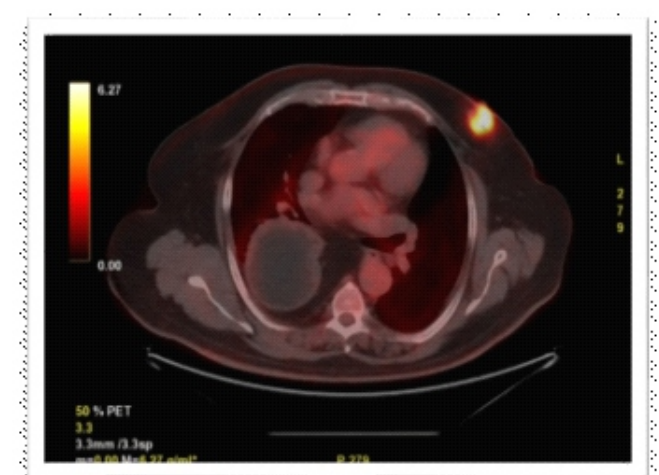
Axial FDG-PET/CT: Intense uptake in left breast retro-areolar mass (SUVmax 8.6), confirming primary breast cancer.
